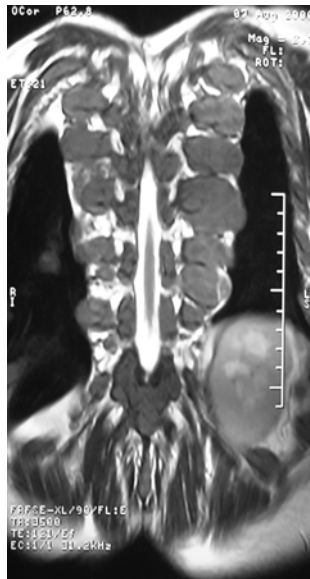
Postoperative MRI after first surgery showing decompressed spinal cord from T8-T12 with a new extradural haematopoietic tissue compressing the spinal cord at upper levels T2-T4.
